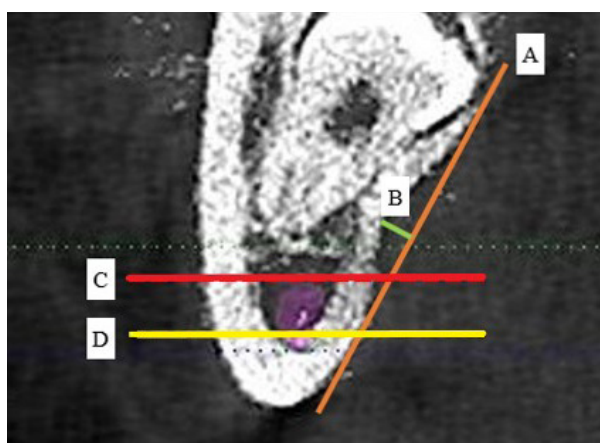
Lingual concavity depth measurement on cross-sectional reconstructed images of cone beam computed tomography scans and the level of depth in relation to the level of inferior alveolar canal. Line A – from the upper to lower bony prominences of concavity. Line B – perpendicular to line A from the deepest lingual concavity and distance measured. Lines C and D – superior and inferior borders of the inferior alveolar canal
